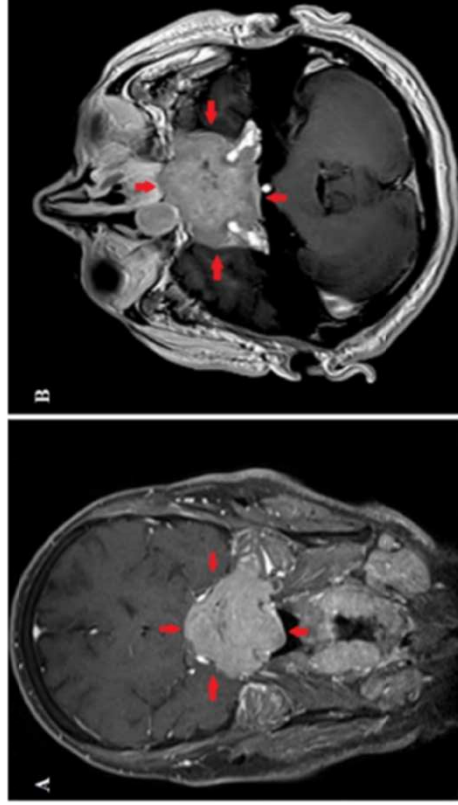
Coronal (A) and axial (B) T1-weighted magnetic resonance images with contrast showing a large unresectable sphenoid sinus tumor.
